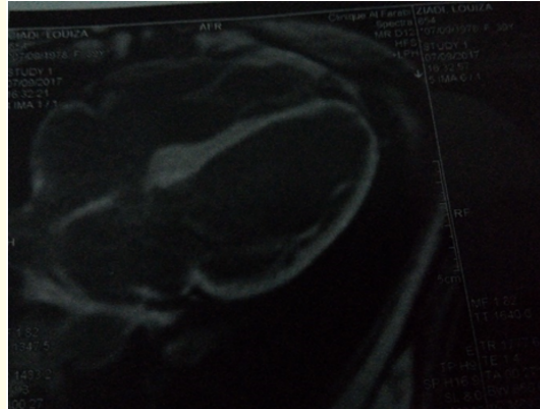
Thoracic MRI showing a hydatid cyst of the interventricular septum with multivesicular content.
